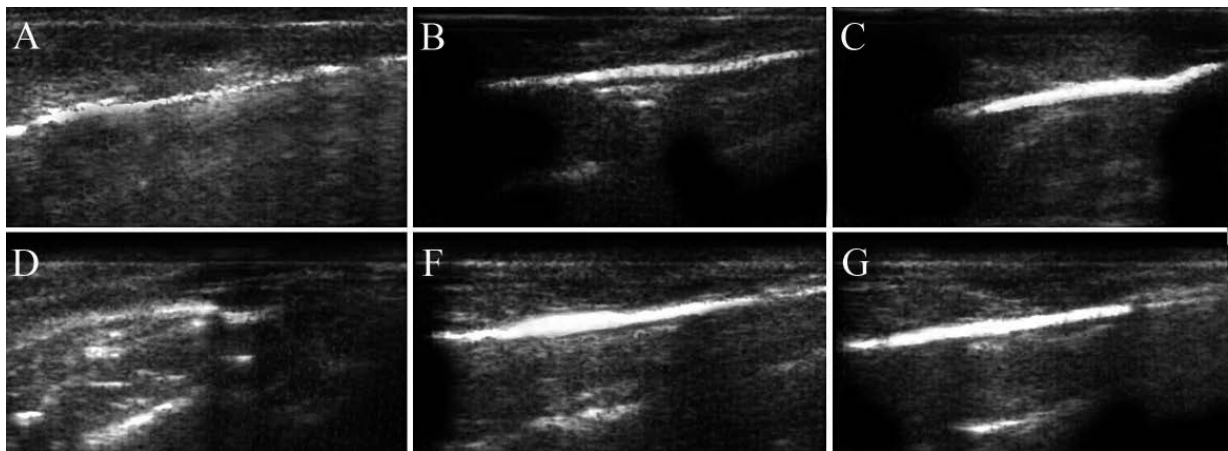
Plain ultrasonography of the rabbits Achilles tendon, 120 days after injury. The echogenicity of the injured area of the injured control tendon (A and D) is low, and the injured area shows an amputated view. The tendinous structure in the defect area is not organized in this group (D). Peritendinous adhesions are also seen in the periphery of the injured area with lower echogenicity than the tendinous structure (A). The echogenicity of the injured area is not homogenous (A and D). In the injured tendons treated with collagen implant (B and F), no amputated view is seen in the injured area and the defect is filled with the newly regenerated fibrous connective tissue in a similar patterns to normal tendon (C and G). But the echogenicity of the injured treated tendons is still slightly lower than the normal tissue. The peritendinous adhesions are not diagnostic in these tendons, and the diameter of the newly regenerated tissue is larger than the injured area of the control tendon.
